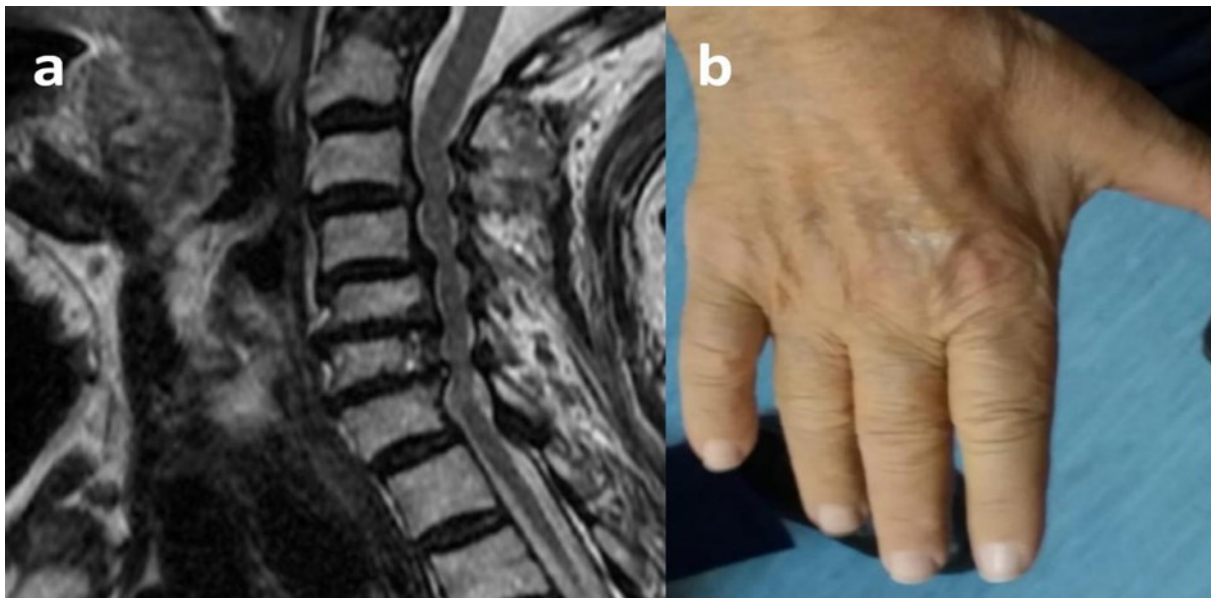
Cervical MRI of a patient (case 7) with cervical spondylotic myelopathy (a) and right hand with marked intrinsic muscle atrophy (b).
